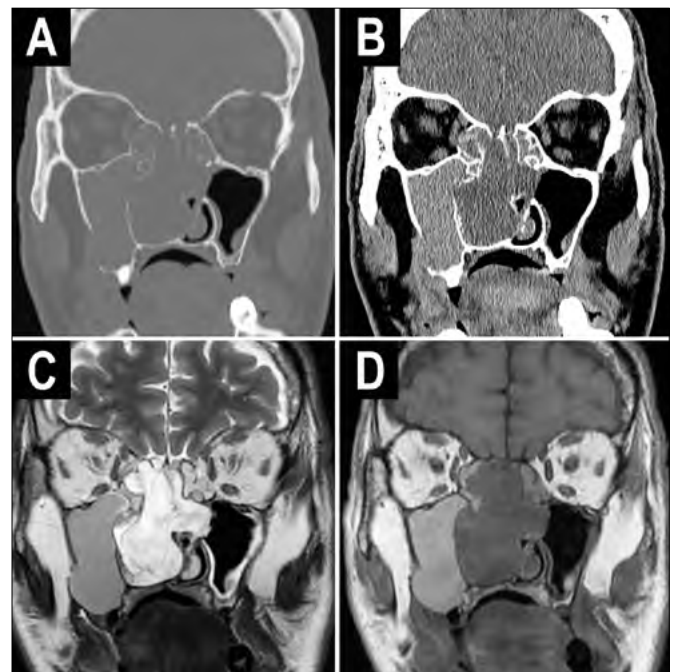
Computed tomography (A, B) and magnetic resonance imaging (C, D) of a mucinous, signet-ring cell, intestinal-type adenocarcinoma of the right nasoethmoidal complex. Different imaging modalities allow depiction of tumour extension with respect to the most relevant adjacent compartments (*i.e.* orbital cavity, skull base).
